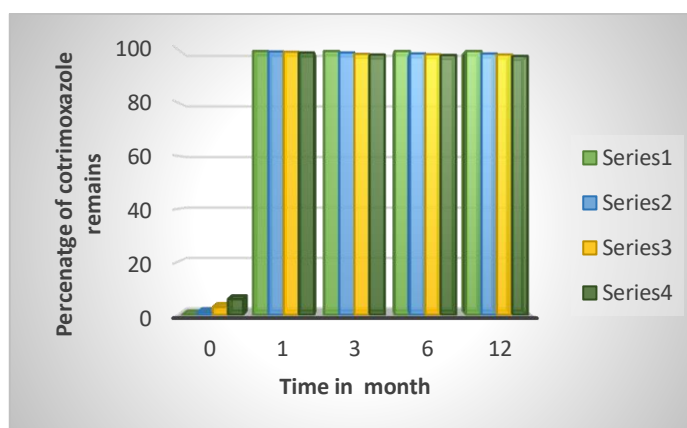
Mean retention of cotrimoxazole into SLNs from F12 CT-SLNs Gel
